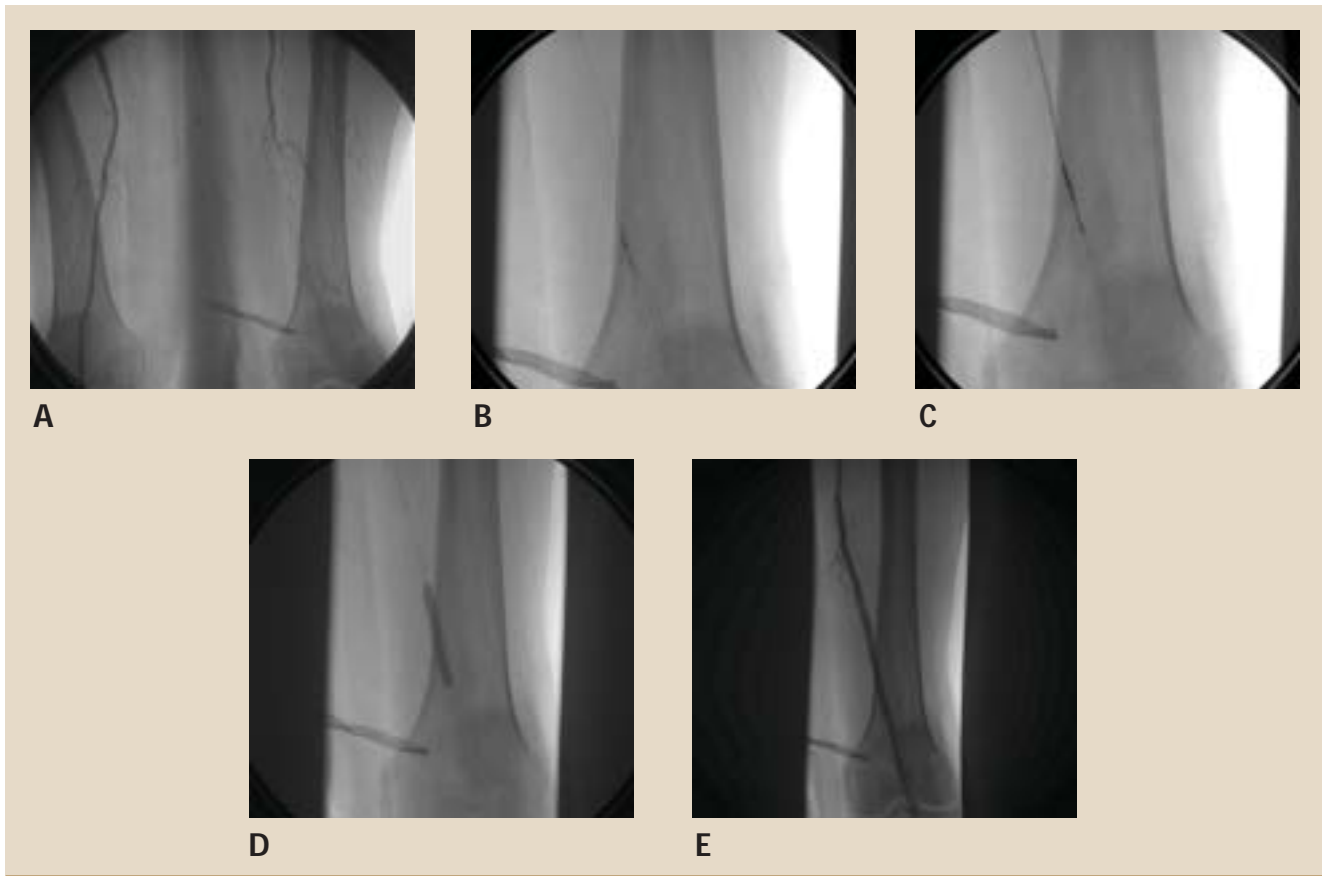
Percutaneous recanalization of an occluded left superficial femoral artery (SFA) in a patient with severe, lifestyle-limiting intermittent claudication. The resting ankle-brachial index on the left side was 0.64, which dropped to 0.43 with exercise. Angiography (A) showed a completely occluded long segment of the left SFA. The wire was purposefully passed into the subintimal part of the vessel (B). A Pioneer™ catheter (Medtronic, Minneapolis, MN) was placed in the subintimal space over the wire (C) and, with intravascular ultrasonographic guidance, the true lumen of the distal SFA was entered with a needle and a second wire was passed through that. Balloon angioplasty was performed with a 5 mm x 40 mm balloon (D), and overlapping 7 mm x 120 mm and 7 mm x 40 mm nitinol self-expanding stents were placed (E), producing an excellent angiographic result. Historically, this sort of lesion was treated conservatively or, if the symptoms were disabling, with open surgery. With current endovascular technology, percutaneous revascularization is often possible.
